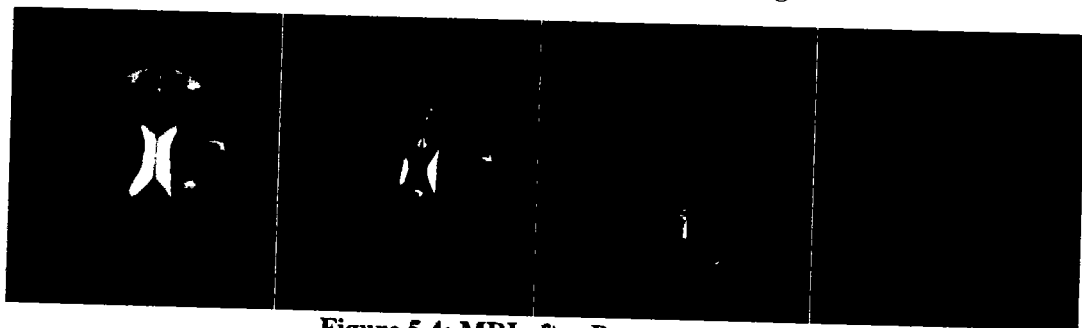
MRI after Preprocessing
